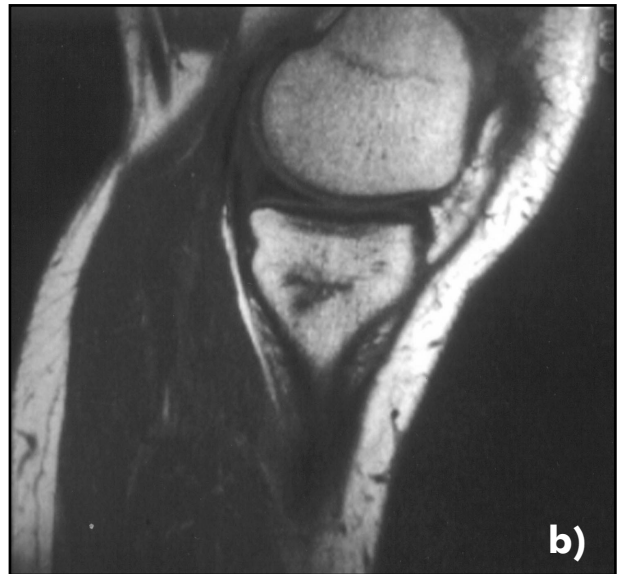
MRI of the knee of a 49-year-old woman on dialysis is for end stage renal disease, with recent onset of knee pain.
